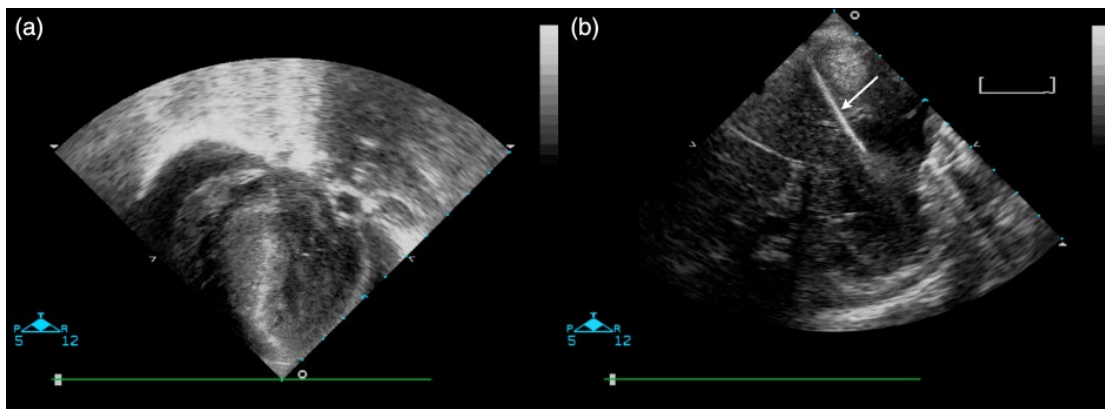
(a) TEE image of pericardial effusion. (b) Transthoracic image of pericardiocentesis needle (arrow) entering a pericardial effusion.
